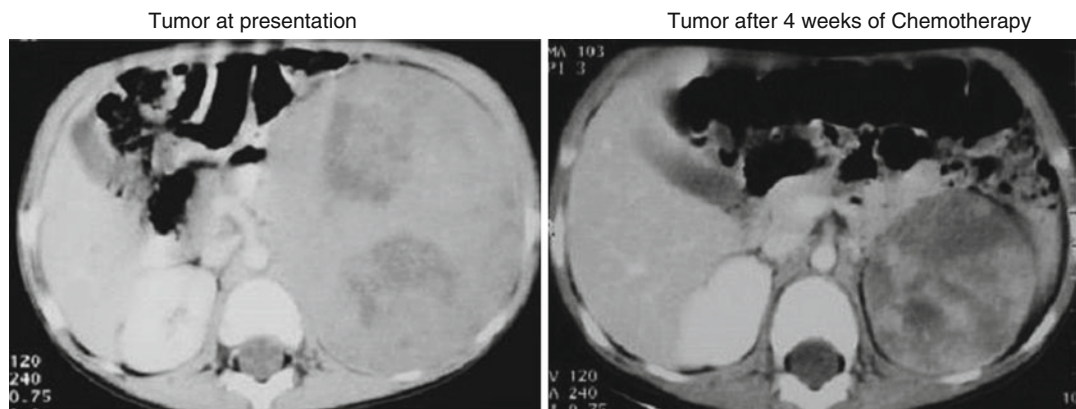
Computed tomography scans demonstrating a picture of a Wilms' tumor at presentation and following 4 weeks of chemotherapy
